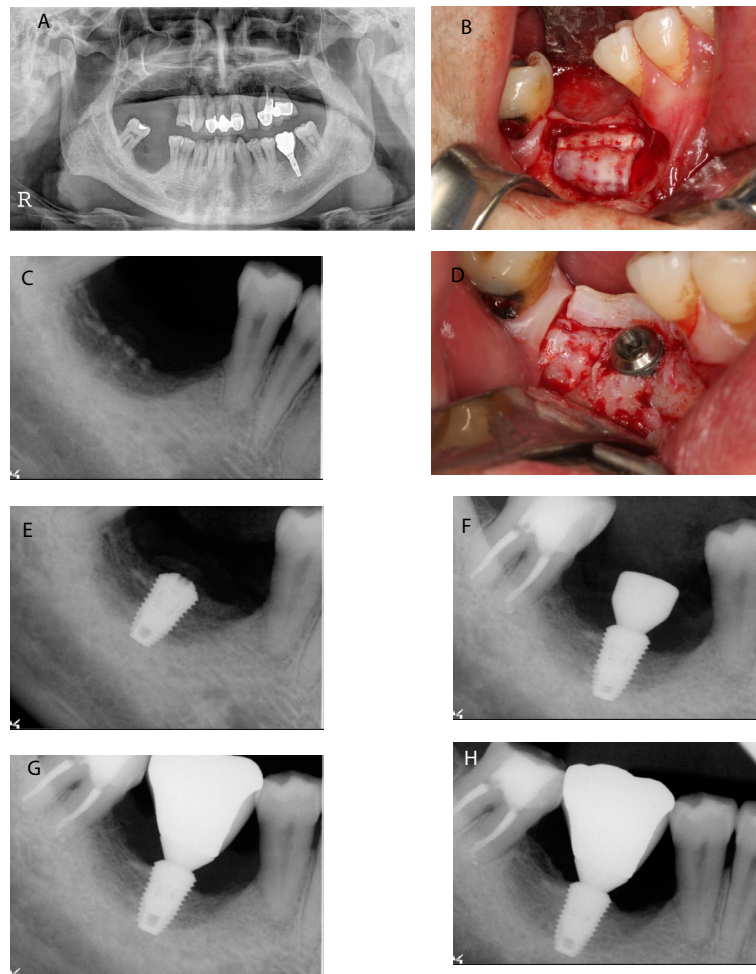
A case of ridge augmentation using autogenous tooth bone block and chips followed by implant placement in a 39-year-old male patient. A. Pretreatment panoramic radiograph. Notice that the absolute short distance between the residual ridge crest and inferior alveolar nerve canal B. Autogenous tooth bone chips and block (sheet-formed) had been grafted in the site C. Postoperative periapical radiograph D. 6 months later, autogenous tooth bone block was still remained on the graft site and no severe graft material resorption was detected. Then the implant fixture was installed E. Periapical radiograph after implant placement F. The 2nd surgery was done after 3 months. Notice that the peri-implant bone density is getting denser G. Periapical radiograph after prosthetic delivery H. Periapical radiograph 15 months after prosthetic loading.
